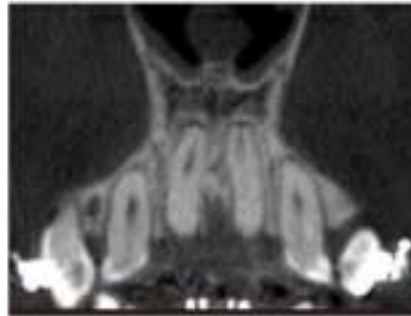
Root resorption of upper incisor after contact with incisal canal CBCT—coronal plane.
